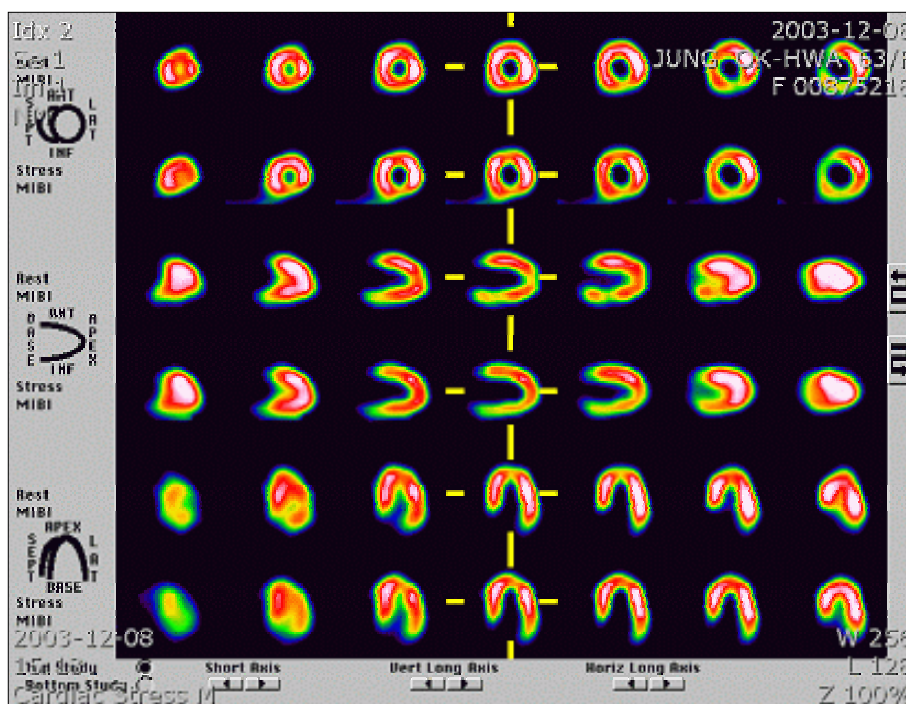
Myocardial SPECT-99mTc showing no perfusion defect in either the resting or stress phases.
